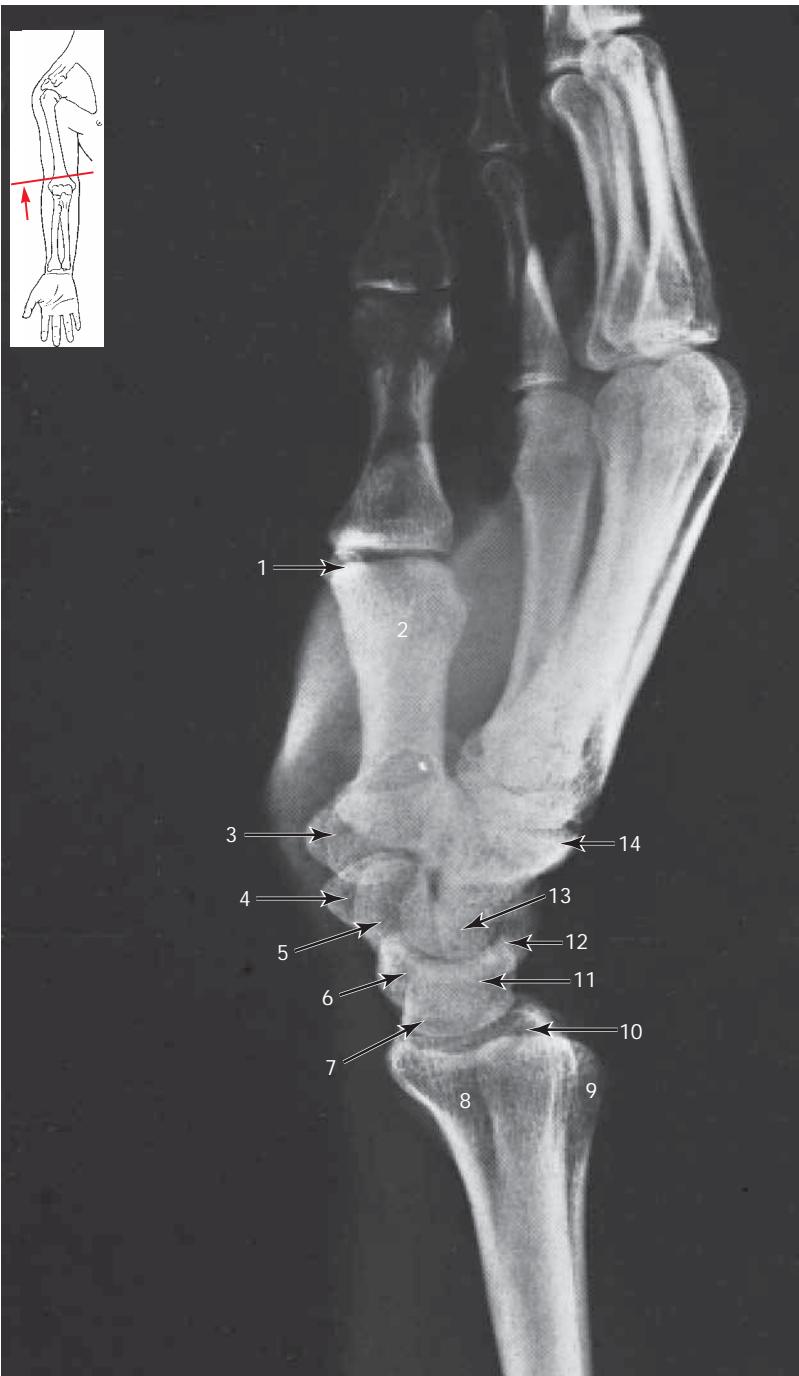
Radiograph of the Right Hand (Lateral Projection)
